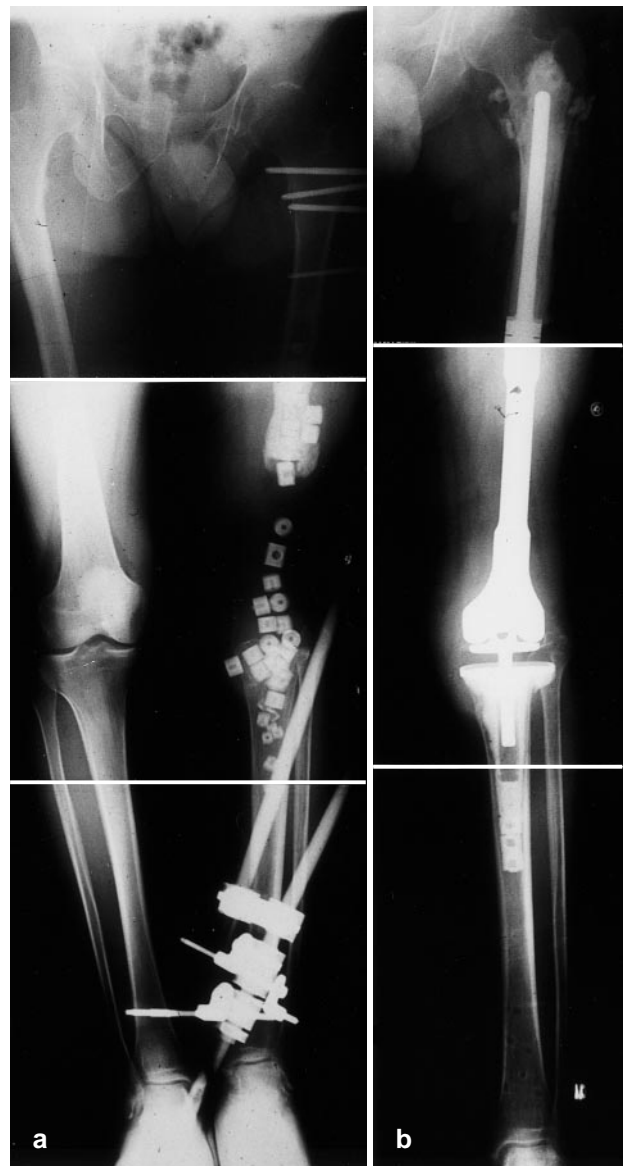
Radiographs after the first (a) and second (b) stages of treatment for chronic osteomyelitis around a megaprosthesis inserted after resection of the distal femur for osteosarcoma in a male aged 40 years. The infection was apparent two years after initial treatment, and did not respond to systemic antibiotic administration. The first stage was to remove the prosthesis and surrounding infected tissues, insert CHA ceramic impregnated with Flomoxef sodium and Gentamicin sulfate (as no causative organism was cultured), and to support the limb
